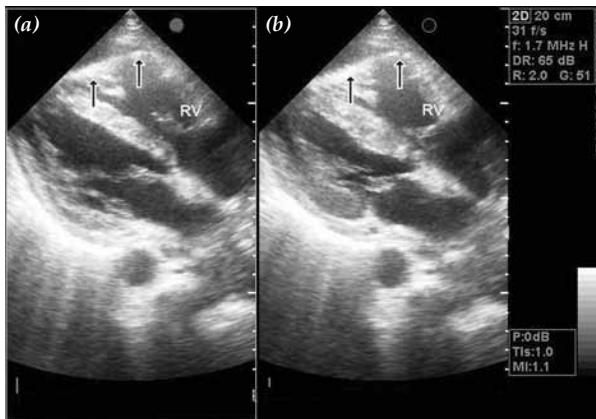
Apical 4-chamber view of right ventricle in diastole (a) and systole (b) showing akinesia of RV apex and midfree wall.
